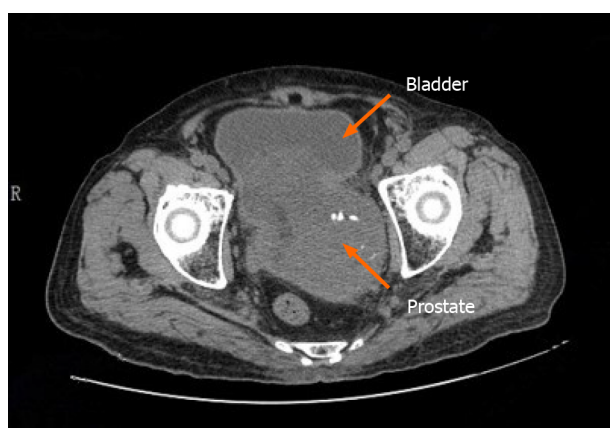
A follow-up pelvic computed tomography revealed that the prostate was enlarged in size with irregular morphology. The prostate gland protruded locally to the bladder with uneven density. Patchy, low-density shadows and punctate calcification can also be seen in the prostate gland with an unclear boundary between the prostate and bilateral seminal vesicles gland.
